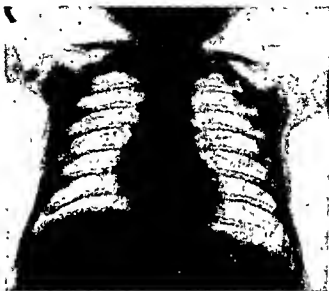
SAME CASE AS FIG. 90 THREE WEEKS AFTER X-RAY APPLICATION TO REGION OF THYMUS
